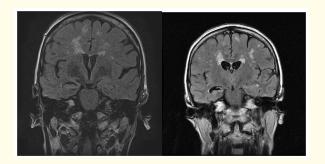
MRI - FLAIR sequence: Progressive R hippocampal atrophy (August 2018) and (March 2021).
